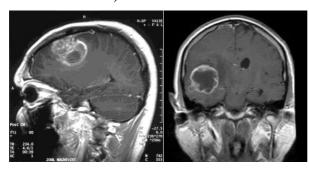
Glioblastoma multiforme images obtained by MRI. GBM appears as a large mass surrounded by vasogenic oedema with a necrotic centre (from Wikipedia and Radiopaedia).
